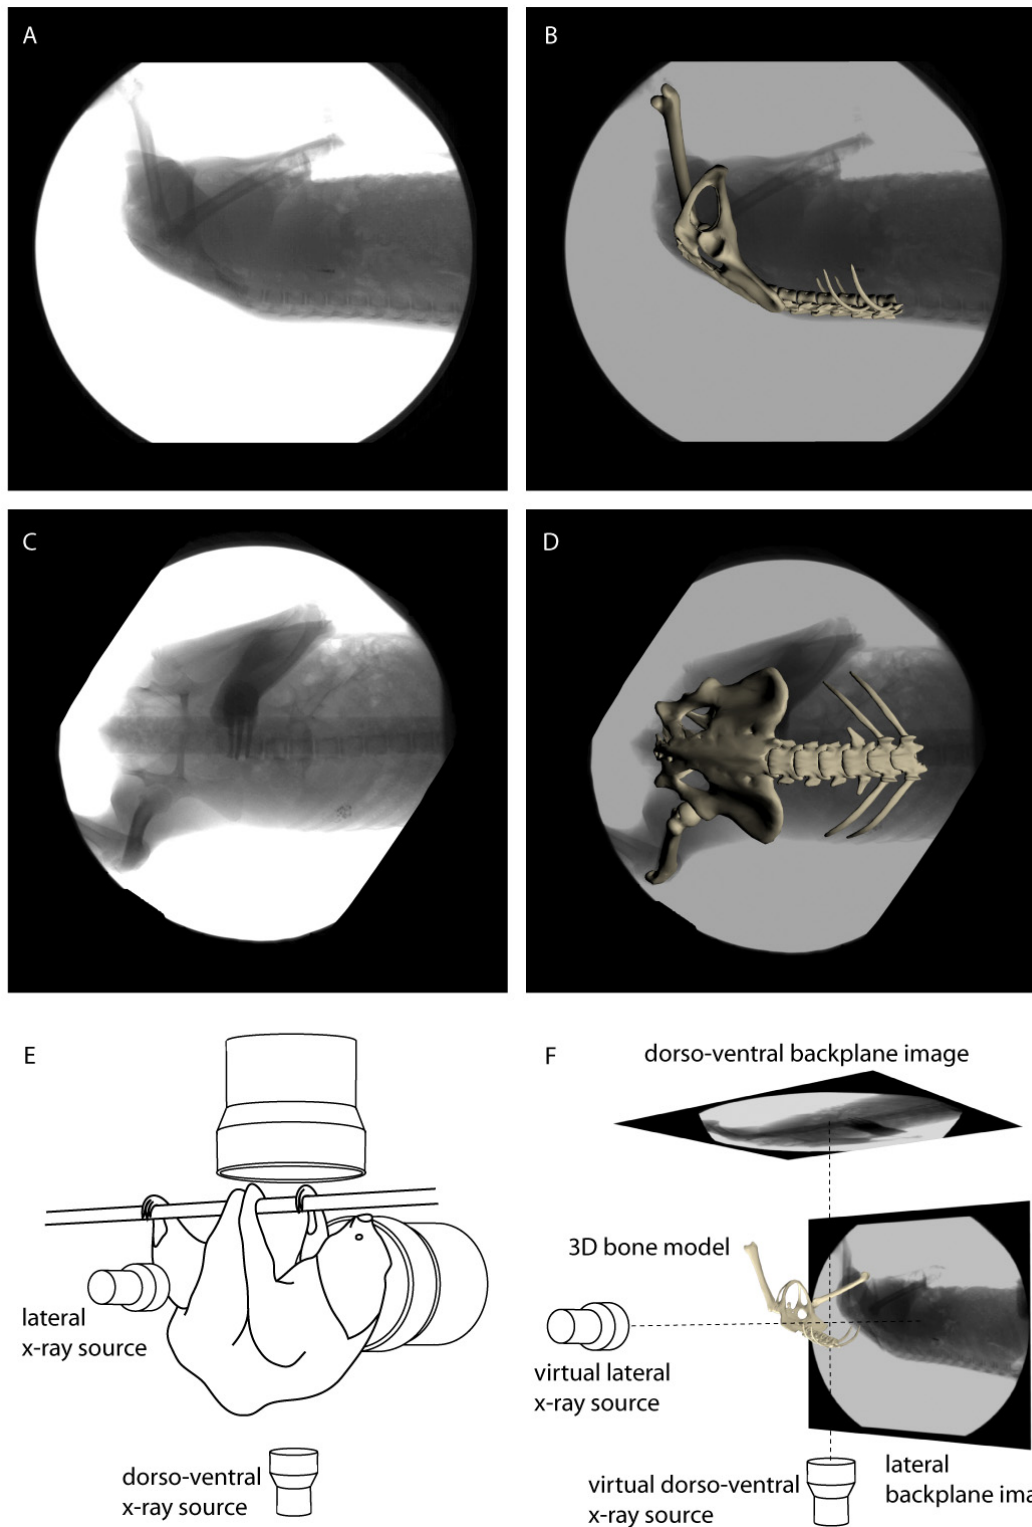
'Scientific rotoscoping' (Gatesy et al. 2010). A virtual marionette is posed to match the x-ray shadow of synchronously recorded latero-lateral (A, B) and dorso-ventral (C, D) x-ray videos. To achieve this, the experimental setup (E) is 3D calibrated and virtually recreated within 3D software Maya (F). For further explanation see text.
